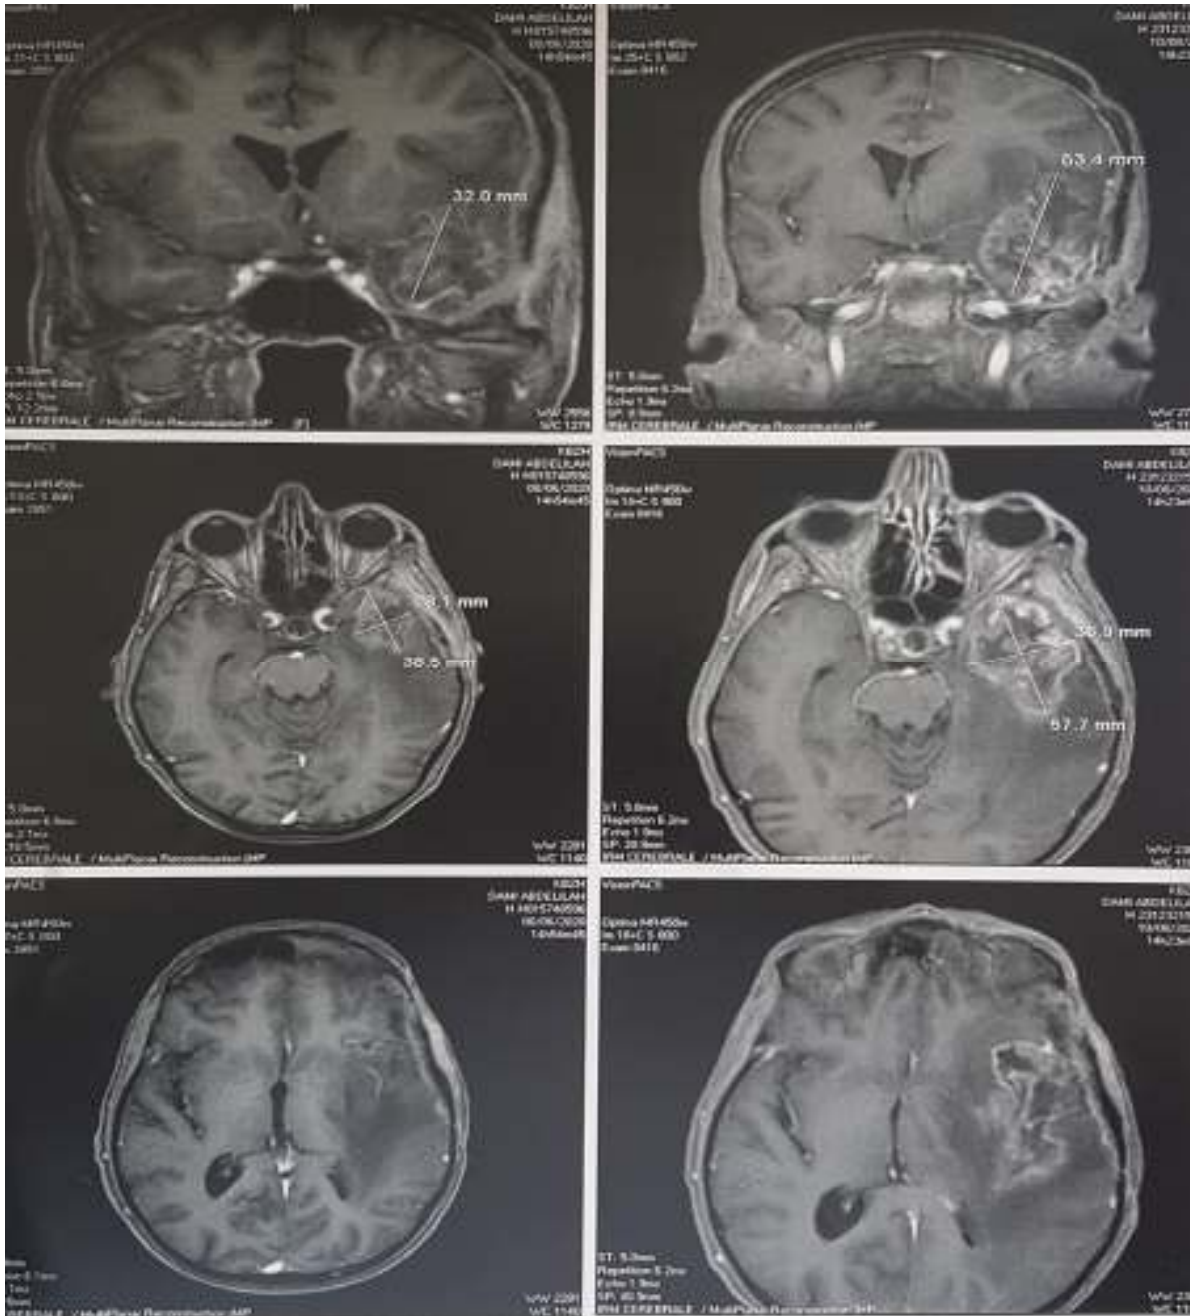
preoperative MRI of a 60 years old patient suffering from a left temporal glioblastoma.
